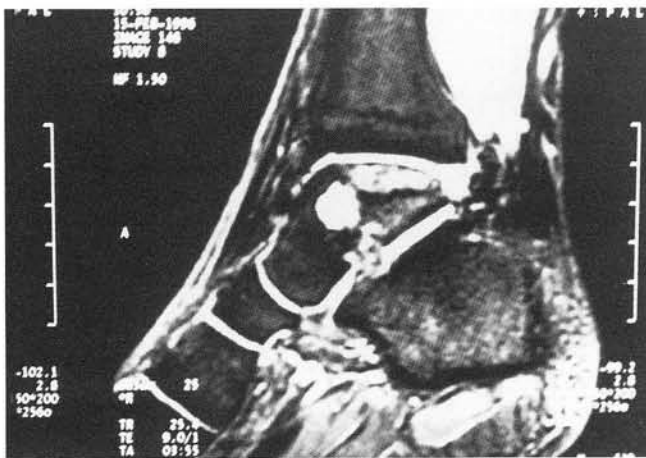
Sagittal T-2 MRI image.
